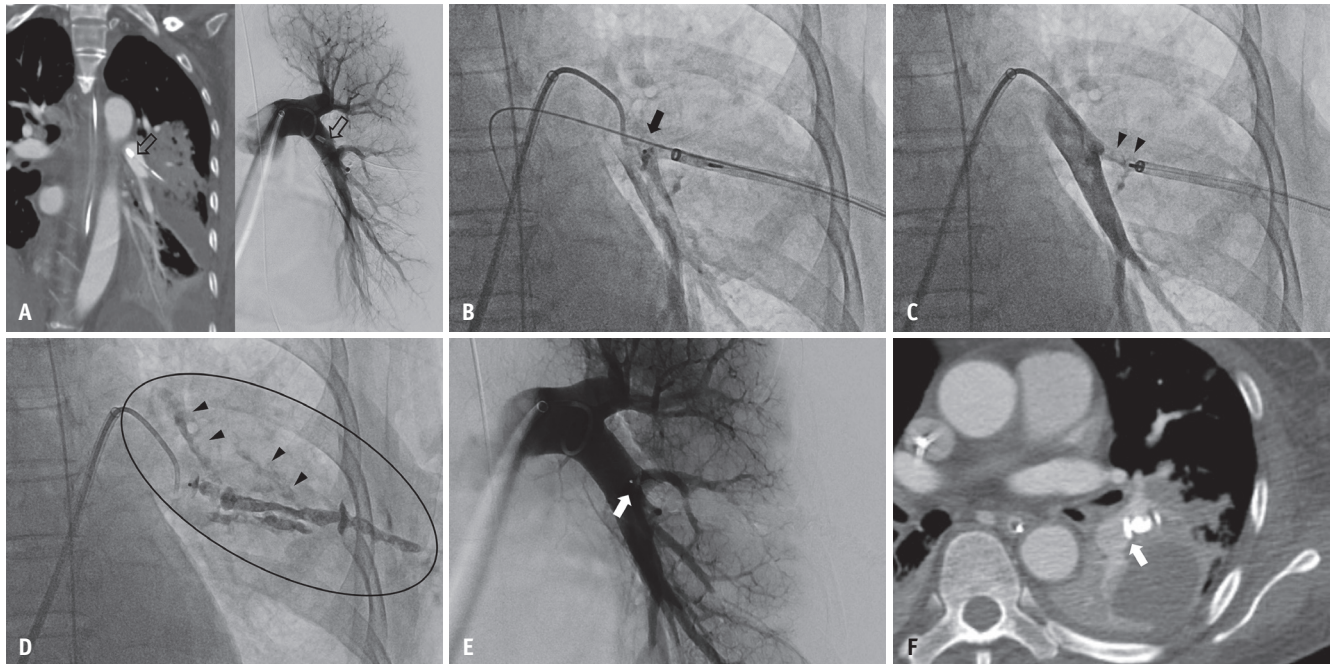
Images from the case of a 65-year-old female with iatrogenic central pulmonary artery injury. A: The chest tube (arrows) penetrating the left lung parenchyma is visualized on the CT image (left image), a finding confirmed on pulmonary arteriography (right image). B: An 8-mm AVP type II is inserted through the sheath. The first disc (arrow) is released inside the vessel and is slowly withdrawn to anchor the first disc portion of the AVP inside the vessel. C: The sheath is withdrawn, and the remaining two discs (arrowheads) are deployed at the chest tube tract. Subsequently, the AVP is detached. D: The chest tube tract, along with multiple fistulae (arrowheads) connected to it, is embolized by injecting a 1:2 mixture of N-butyl-2-cyanoacrylate and lipiodol (ellipse). E: A subsequent left pulmonary arteriogram showed no further bleeding, with blood flow mostly preserved to the left lower lobe. The arrow depicts the first disc of AVP in the vessel. F: CT scan image taken 2 days later shows the AVP at the chest tube tract. Only the first AVP disc (arrow) is positioned in the pulmonary artery with preserved blood flow. AVP = Amplatzer Vascular Plug
